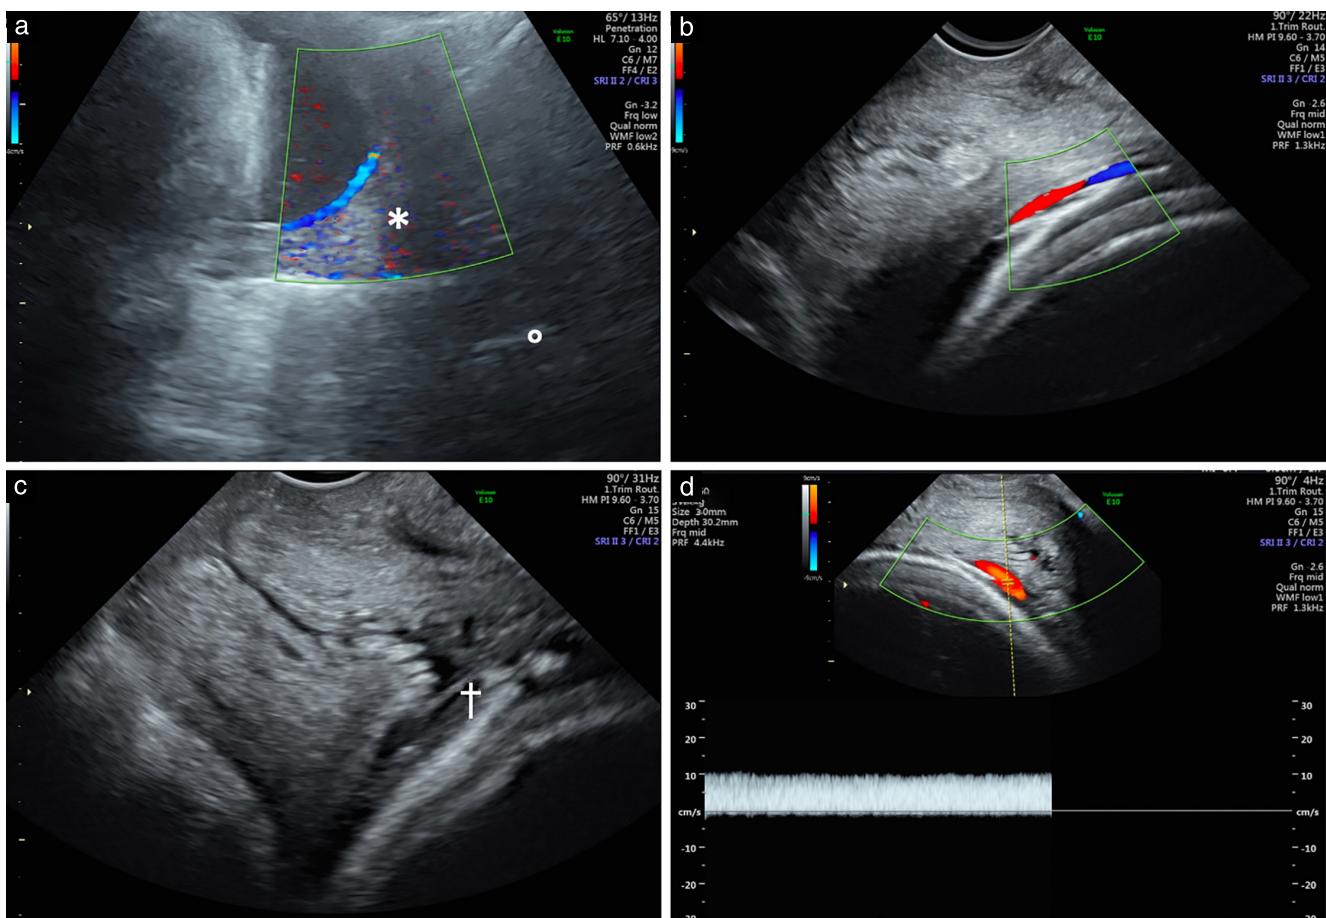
Ultrasound images at 38 weeks' gestation in pregnancy with Type-III vasa previa from our personal experience (Case 1). (a) Transabdominal image of aberrant blood vessel running along amniotic membrane and crossing internal cervical os (*). External os is also indicated (○). (b,c) Transvaginal images with (b) and without (c) color Doppler, showing aberrant vessel (†) crossing internal cervical os. (d) Color and pulsed-wave Doppler indicate venous nature of aberrant vessel with monophasic pattern of flow.
